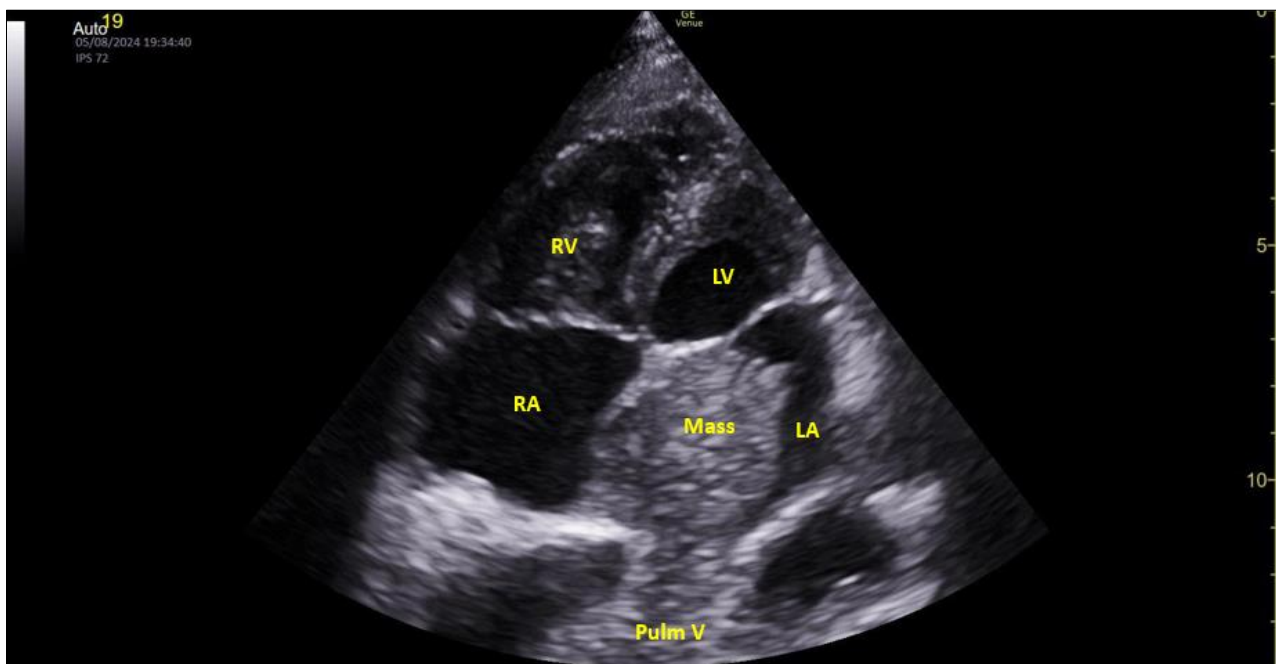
Four-chamber apical view on transthoracic echocardiography showing a mass located in the left atrium (LA) extending into the pulmonary veins (TTE)
